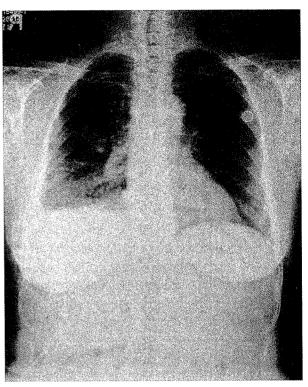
Follow-up 2 weeks later. Chest X-ray film shows the tip of the catheter has migrated to the ipsilateral internal jugular vein.
